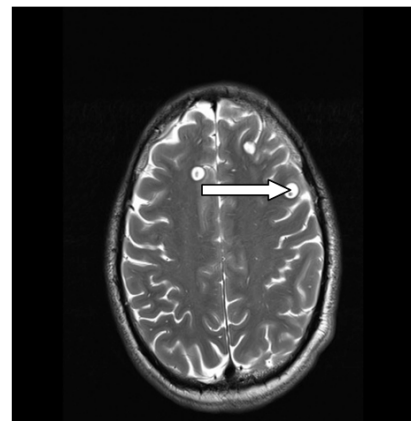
MRI-T2 weighted with contrast
